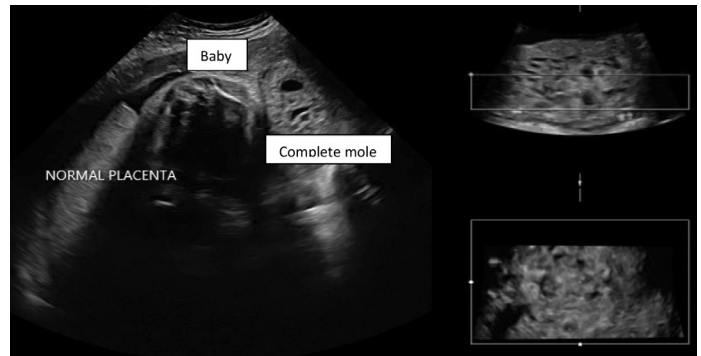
4D ultrasound showing complete mole with co-existing live fetus. The complete mole occupied the posterior uterus with an echogenic uterine mass located at the left posterolateral area with multiple cystic structure situated over the cervical os
